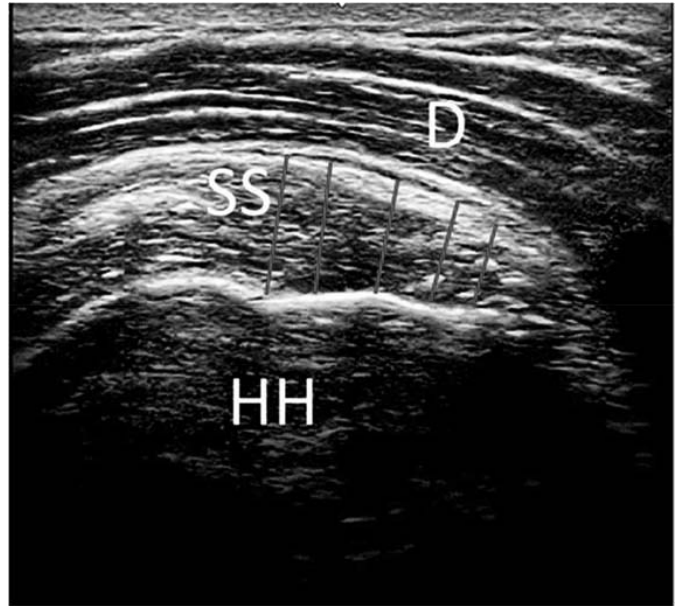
Representative ultrasound image of the supraspinatus tendon (SS), humeral head (HH), and deltoid (D). Vertical lines represent measurement locations along the supraspinatus tendon footprint.
